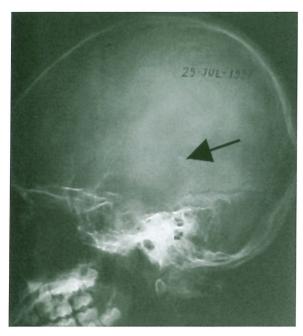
Lateral skull radiograph revealed a clump of intracranial calcification (arrow) in the pineal region.
